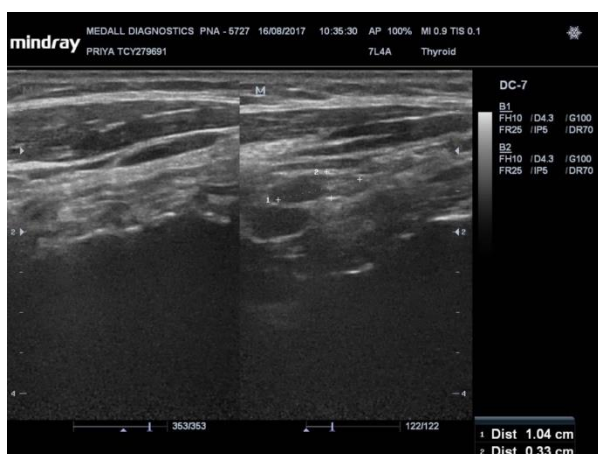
Ultrasound images of normal cervical lymph nodes.
